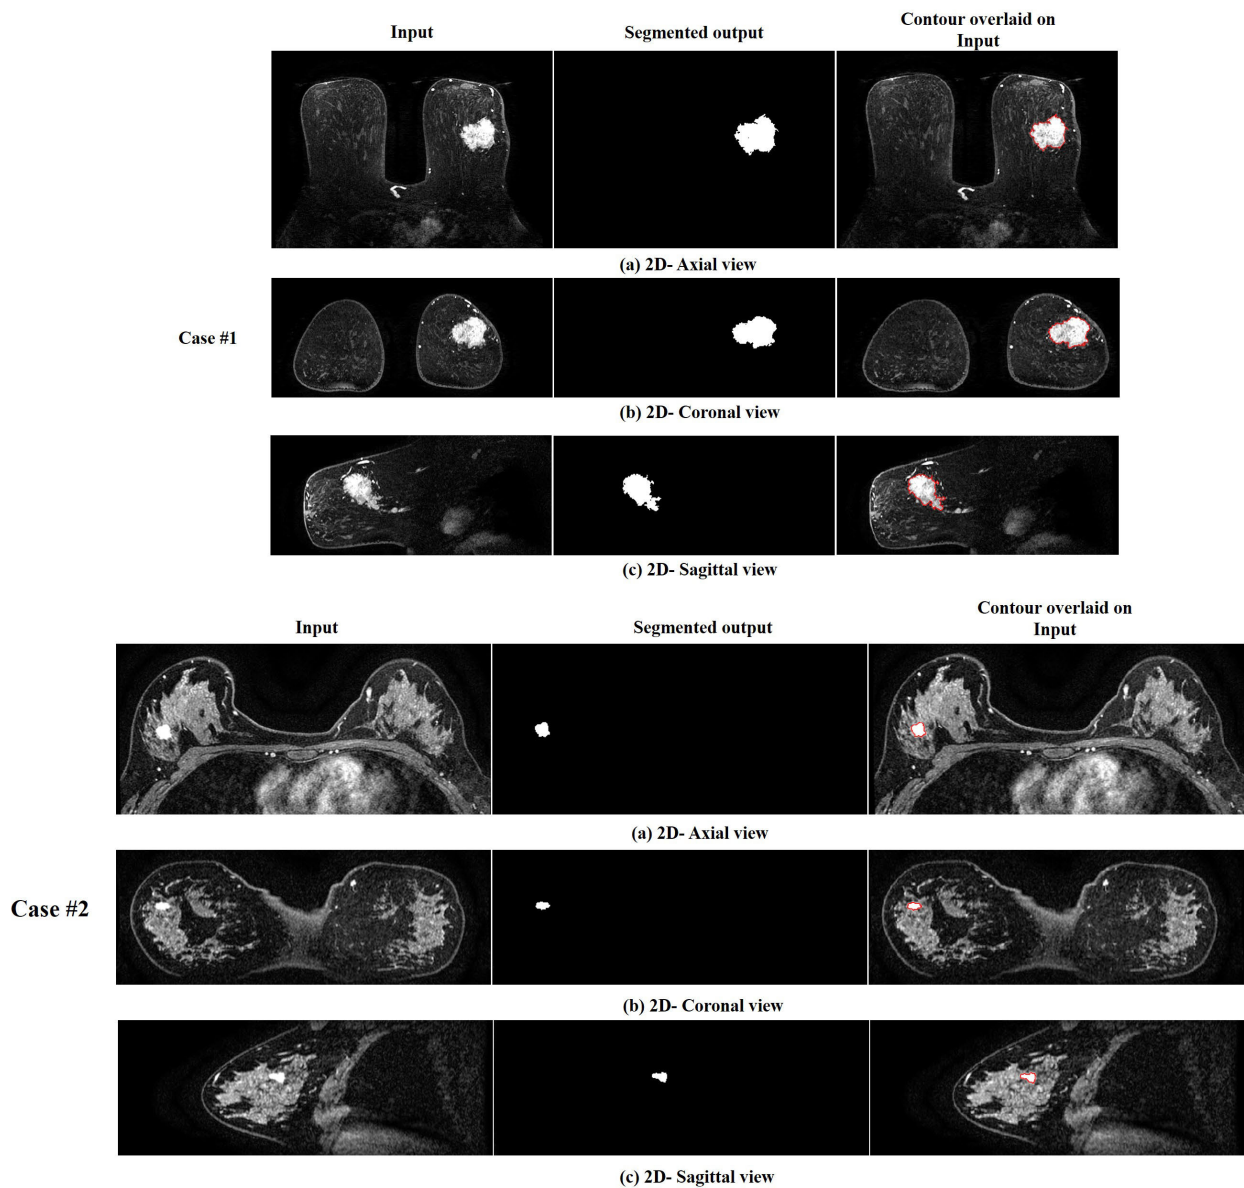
Visuals of 2D DCE-MRI depicting segmentation on three planes (Axial, Coronal, Sagittal) using the BEFVBTS framework (Case #1 and Case #2). Column 1 (Original Input), Column 2 (segmented Output), Column 3 (Contour overlaid on Input).
